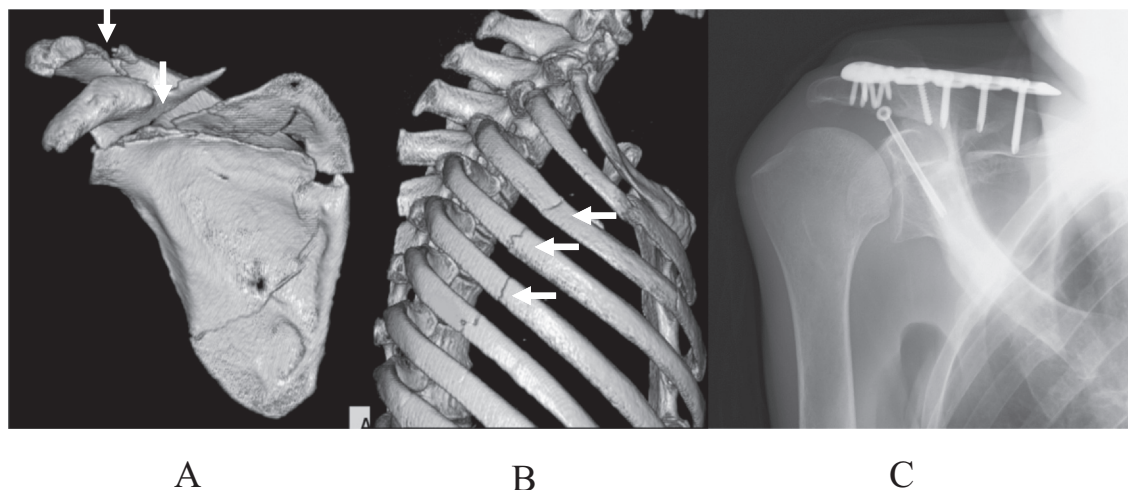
An 83-year-old male. A) Three-dimensional CT demonstrating right Ideberg type III glenoid fracture and acromion fracture. B) Three-dimensional CT demonstrating fractures in the right third to fifth ribs. The right second and sixth through ninth ribs were also fractured. C) Anteroposterior radiograph 3 years after surgery demonstrating no degenerative changes in the right shoulder joint.
